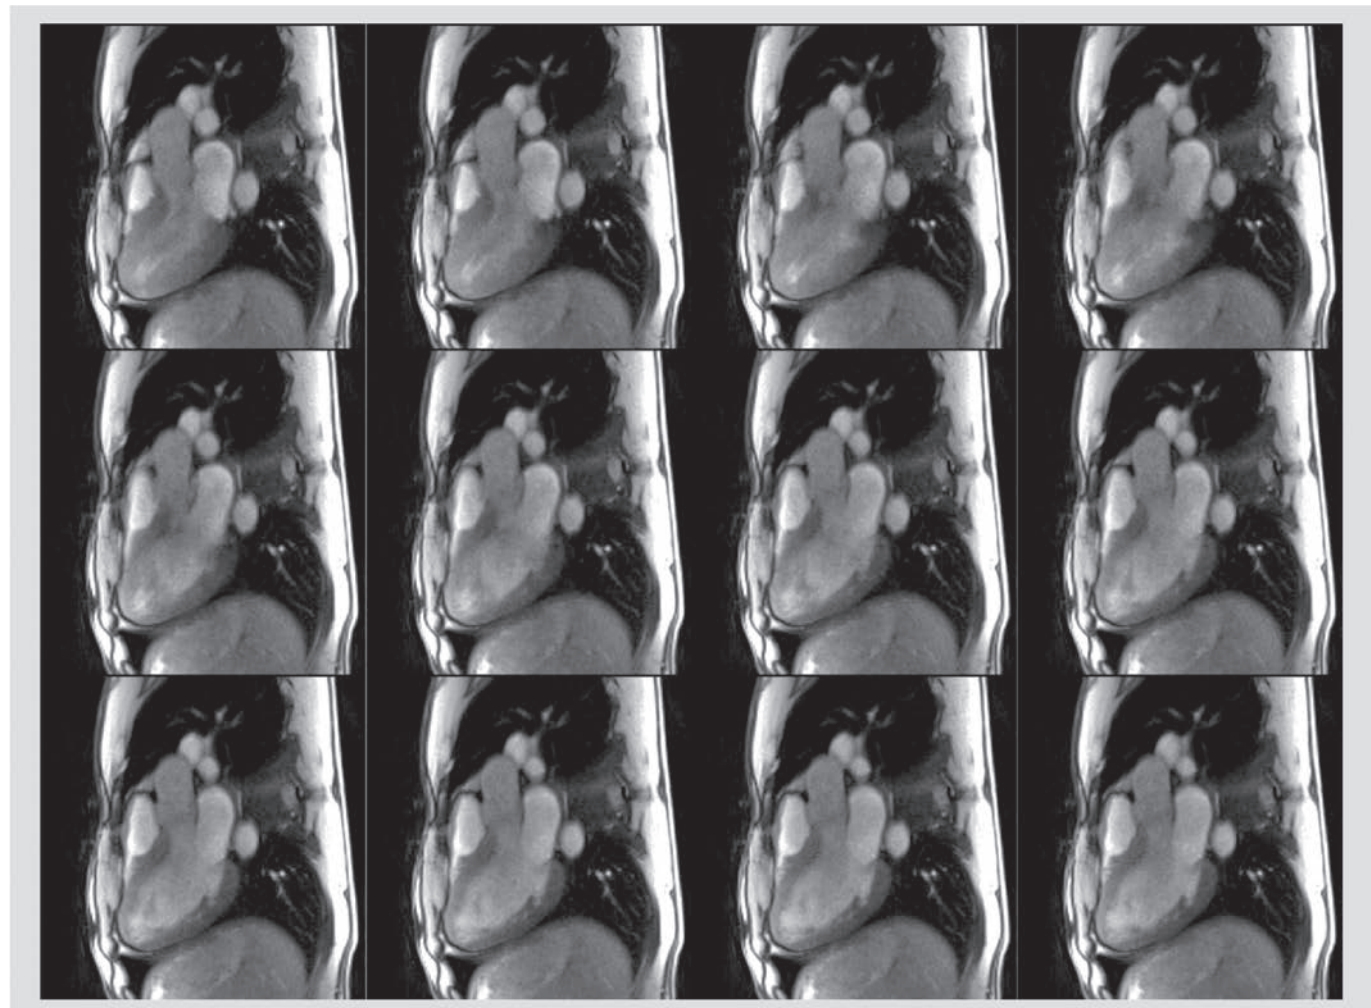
Real-time MRI of the human heart in a three-chamber view. Consecutive frames (top left to bottom right) from a respective movie at 34 ms temporal resolution (30 fps) acquired using radial fast low-angle shot (15 spokes, repetition time/echo time = 2.28/1.46 ms, flip angle 8°, $1.5 \times 1.5 \times 6.0$ mm³). The images represent a 373 ms period of a single cardiac cycle also demonstrating the development of turbulent blood flow in the left ventricle after opening of the mitral valve (top row). See also SUPPLEMENTARY MOVIE 4.
